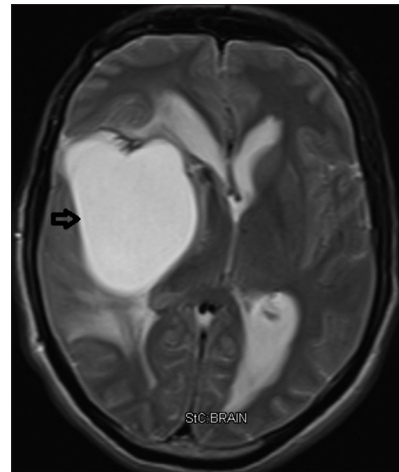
MRI Brain with contrast, 3 years after the first surgery, showing interval development of large cyst (black arrow), causing mass effect with midline shift
